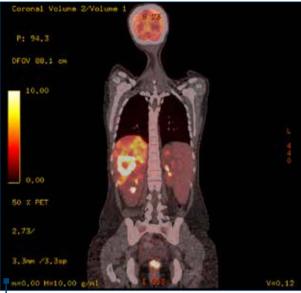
PET-CT Scan with increased uptake liver and rectal areas
